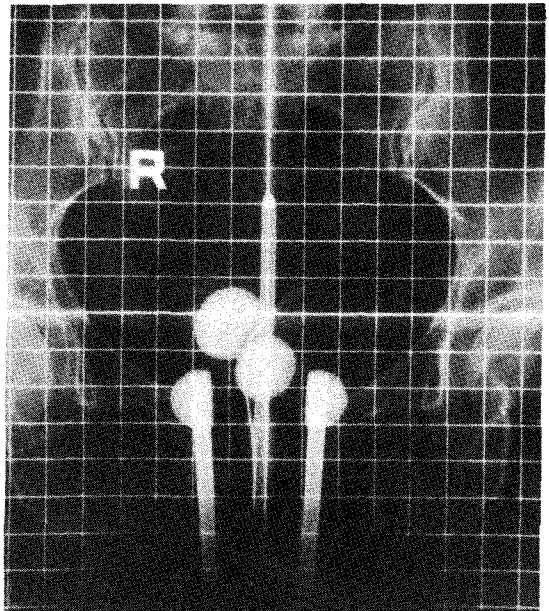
AP radiograph of high dose rate ICR.
